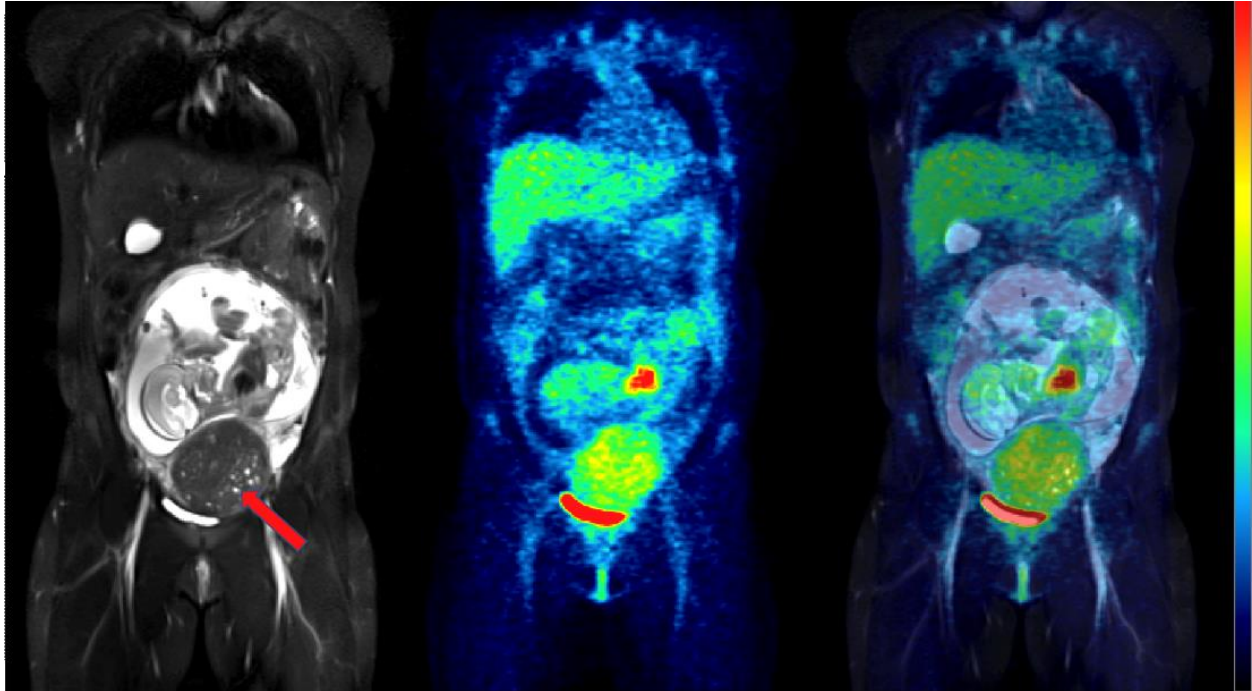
Coronal slices of MRI (left), PET (center), and fused PET/MRI (right) of the same woman in Figure 2, but at 24 weeks of pregnancy. The fetus has visibly increased in mass, but the pattern of ^{18}F -FDG uptake in the organs has not changed, with the heart showing high glucose consumption but the brain still largely silent. The red arrow points to a uterine fibroid.
